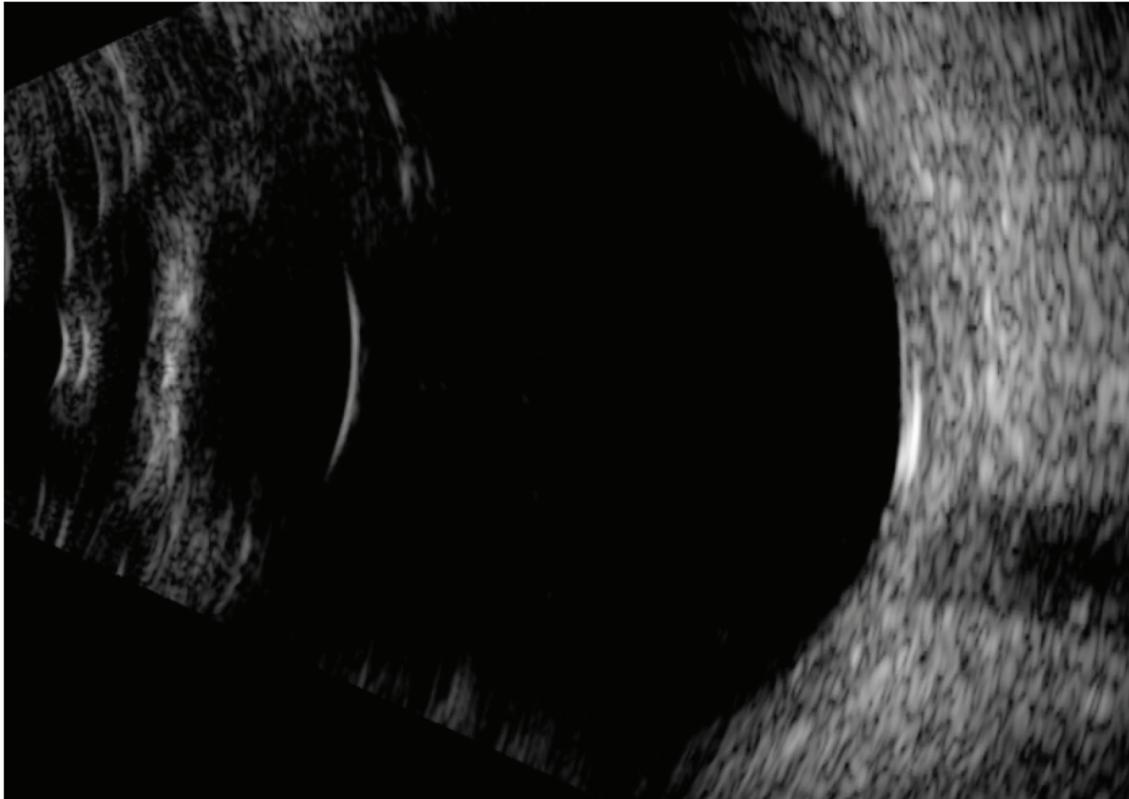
Horizontal axial scan with double corneal arc, double lens arc aligned and optic nerve head visualisation. This scan shows perpendicularity of ultrasound beam against interfaces : optic nerve head visualisation allows to define macular region positioning.
